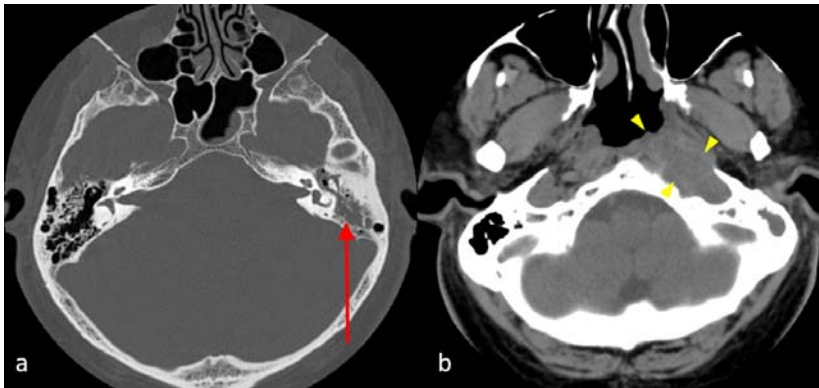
CT of the temporal bones in a patient with chronic left ear pain. a: demonstrates fluid in the left middle ear cavity and mastoid air cells (red arrow). b: A mass was identified at the skull base along the left nasopharynx and retropharyngeal space (yellow arrowheads) obstructing the Eustachian tube. Image courtesy of the University of Massachusetts Medical School, Department of Radiology.
